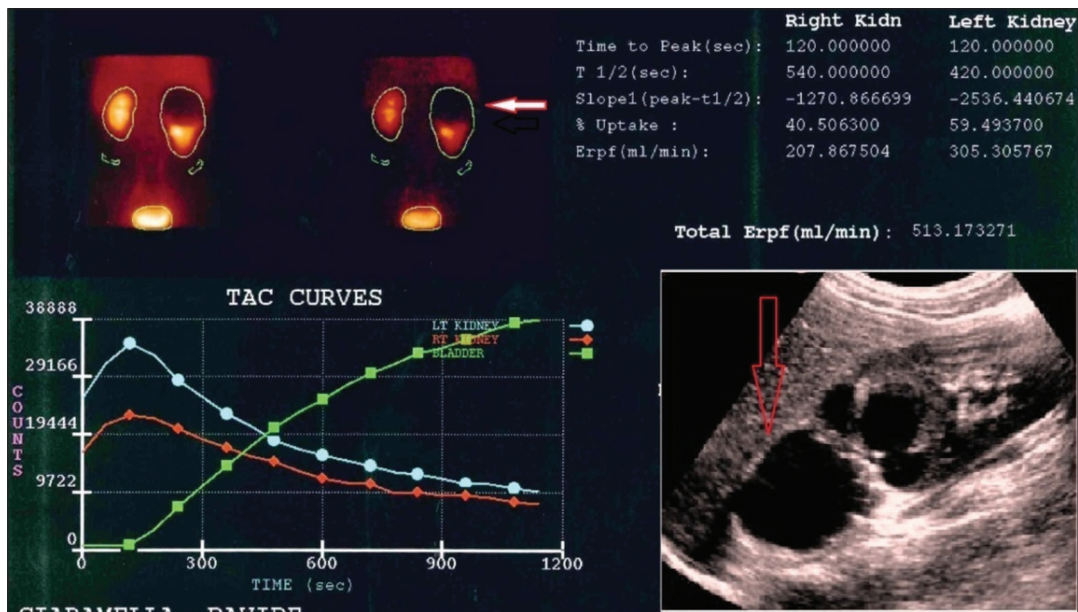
Post-operative epiretinal cyst (ø4 cm): MAG3 renal scan and ultrasound image (red arrows)
